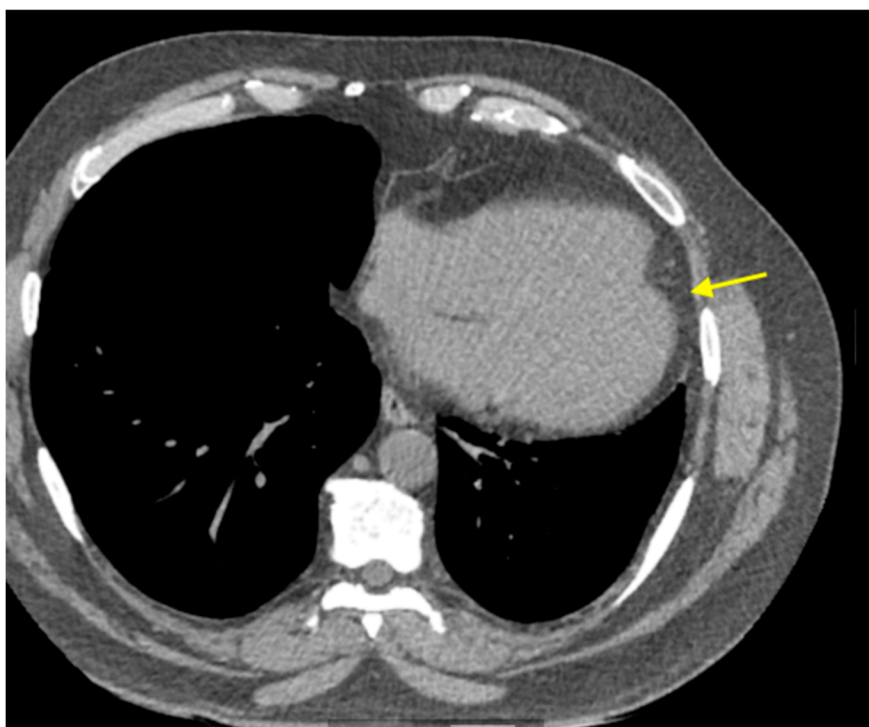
Non-contrast CT of the chest, demonstrating leftward displacement of the heart with associated rotation (yellow arrow).
